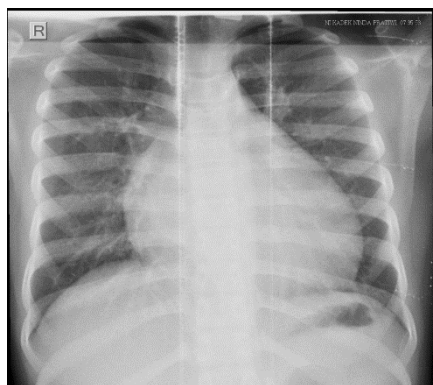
Chest X-ray imaging.
